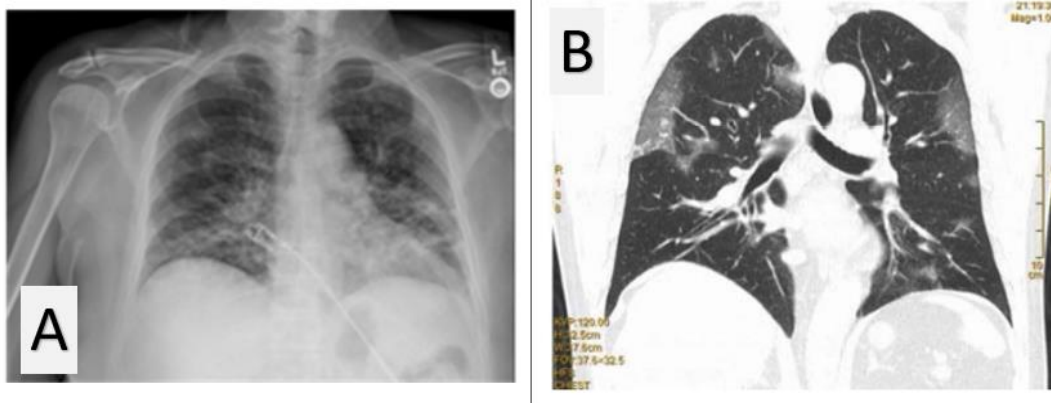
COVID-19 pneumonia radiography and CT scans. (A) X-ray image showing a more prominent bilateral pulmonary infiltrate in the left lung. (B) Image obtained by computed tomography showing areas of increased opacity, islets of opacity are bilaterally distributed in the pulmonary zone. Adapted from [22] and [74].
